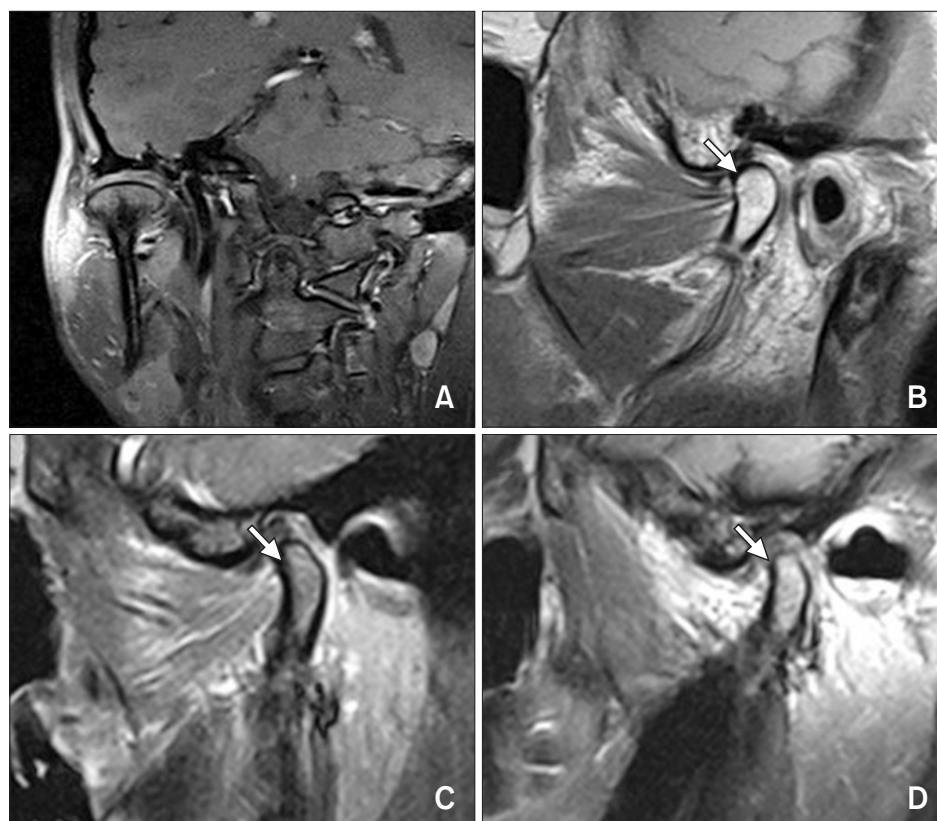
Magnetic resonance imaging (MRI) findings of condyle degeneration. MRI findings show degree of condylar degeneration. (A) Normal relationship between condyle and disc. (B) Degeneration of condyle, beginning (arrow). (C) Degeneration of condyle, intermediate state (arrow). (D) Significant degeneration of condyle and disc (arrow).
